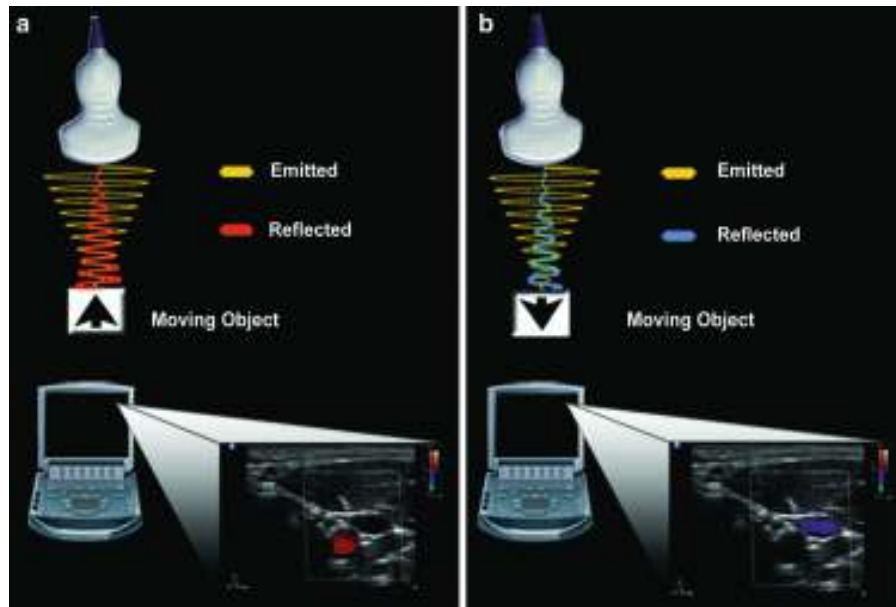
Doppler. (a) When a sound wave is emitted from the transducer and reflected from a target object moving toward the transducer, the returning frequency will be higher than the original emitted sound wave. The corresponding image on the ultrasound machine is represented by a red color. (b) Conversely, if the target object is moving away from the transducer, the returning frequency will be lower than the original emitted sound wave. The corresponding image on the ultrasound machine is represented by a blue color (*Pinzo, 2009*).
